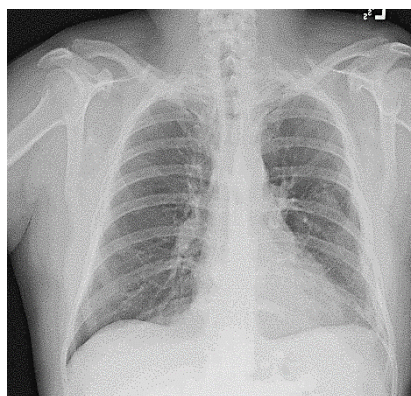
Nodule Chest X-ray
